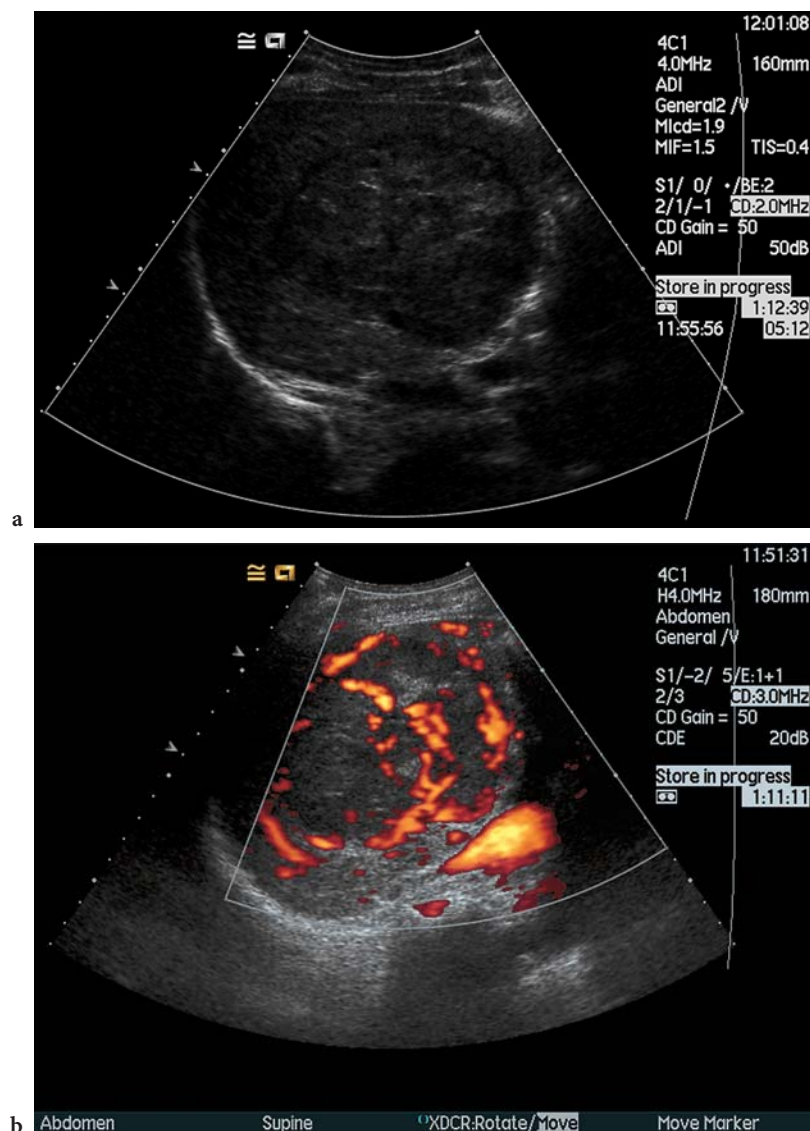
a The heterogeneous texture of large hepatocellular carcinomas is shown in this example which is typically hypervascular on colour Doppler. b The complex, chaotic pattern of the malignant neovascularity is well demonstrated
